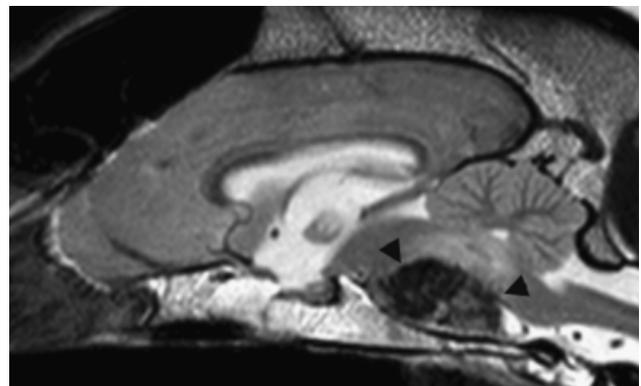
Sagittal T2-weighted image. The mass is heterogeneous and extremely hypointense (arrowheads). The overlying brainstem is compressed and has T2 hyperintensity, suggestive of edema. Hydrocephalus is present rostral to the mass (T2W-TSE, TR = 3000 ms, TE = 80 ms, slice thickness = 2 mm, interslice gap = 1 mm, FOV = 18 × 18 cm, matrix acquisition = 312 × 249).
